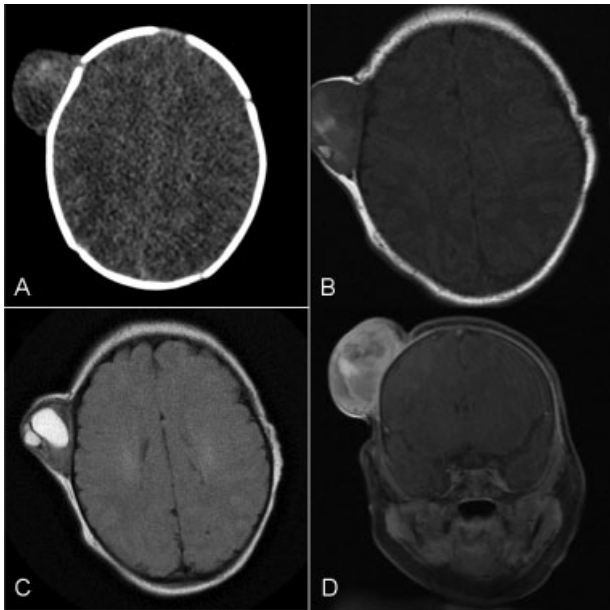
Imaging studies demonstrating right temporoparietal mass. (A) CT of the head—axial image demonstrates large-size extracalvarial mass. (B) Axial noncontrast T1-weighted MRI image. (C) Axial noncontrast MRI T2-FLAIR image. (D) Axial postcontrast MRI T1-weighted image.
